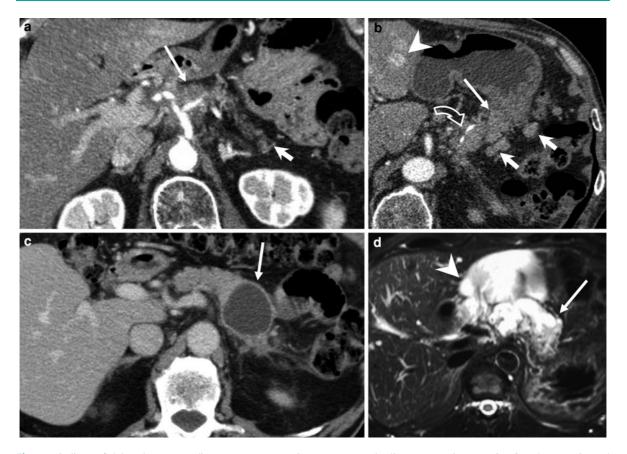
Findings of delayed recurrent disease post- pancreatic surgery MDCT technique: axial images after intravenous contrast medium administration during pancreatic (a, b) and portal venous (c) phases. MR imaging: T2-weighted axial image before intravenous contrast medium administration (d). a Seven months after Pancreaticoduodenectomy with Whipple procedure for pancreatic head adenocarcinoma, MDCT imaging follow-up shows hypovascular infiltrating soft-tissue mass (*arrow*) with encasement of celiac artery, localized on pancreatic bed, on the *right* side of atrophic residual pancreatic tail, MDCT imaging follow-up shows irregular soft-tissue mass (*arrow*) with gastric infiltration, near metallic staples of pancreatic remnant cut edge (*curve arrow*).
